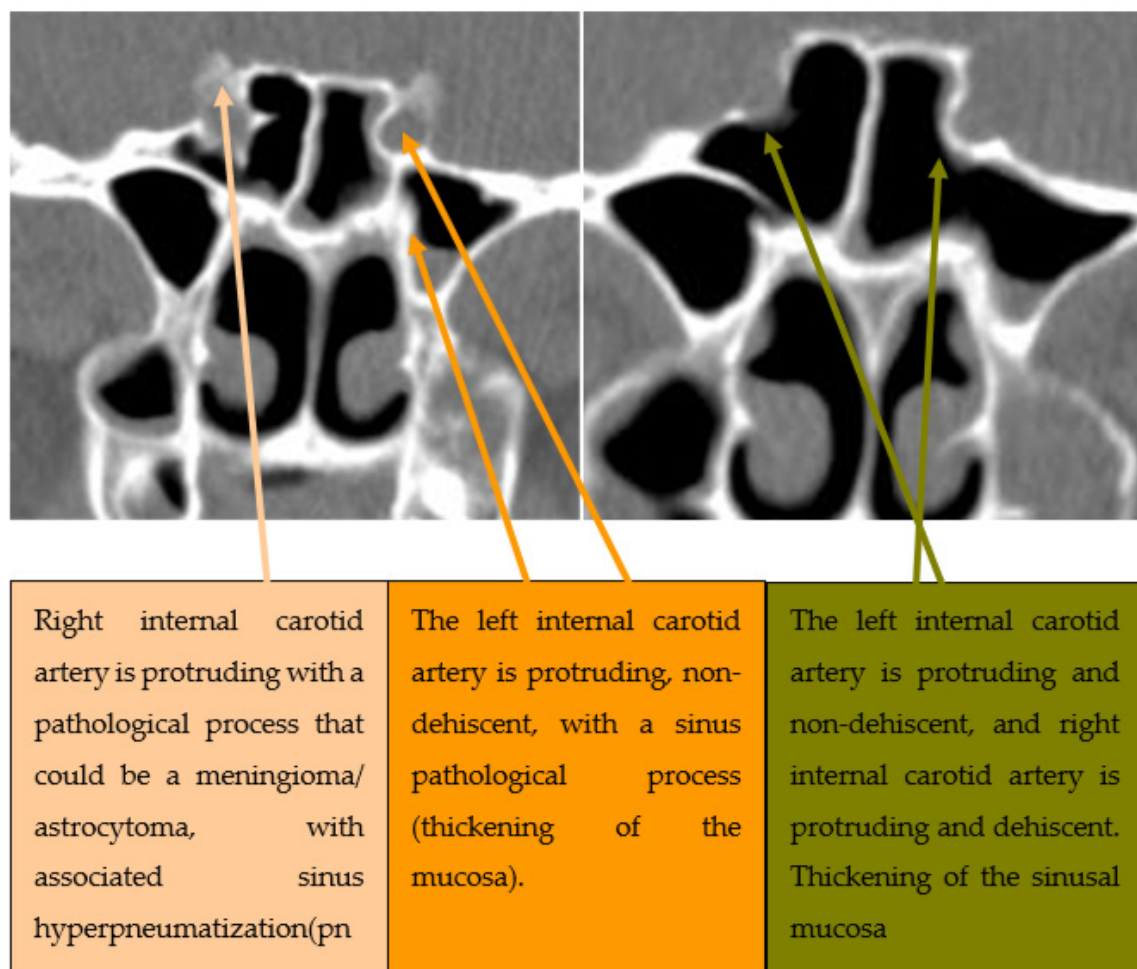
Coronal CT section of paranasal sinuses. Various degrees of protrusion of the internal carotid arteries.
